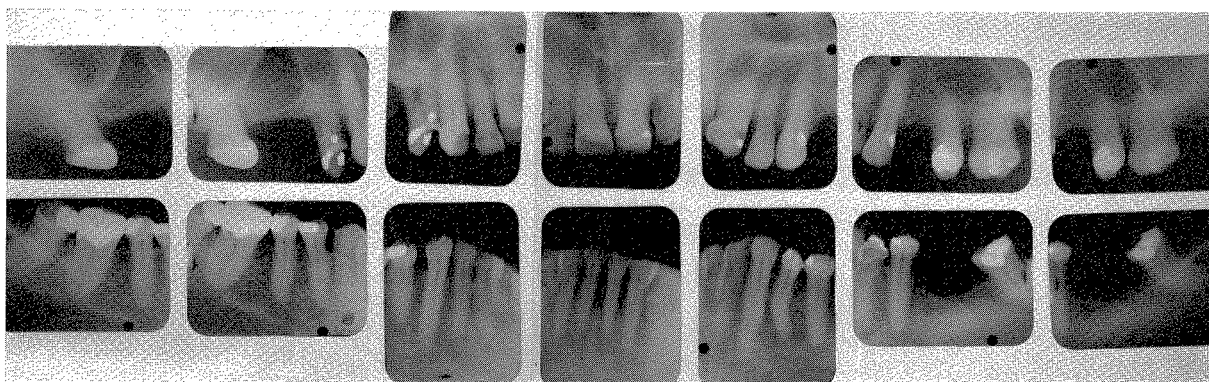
Roentgenograms taken at the start of treatment (1944).
